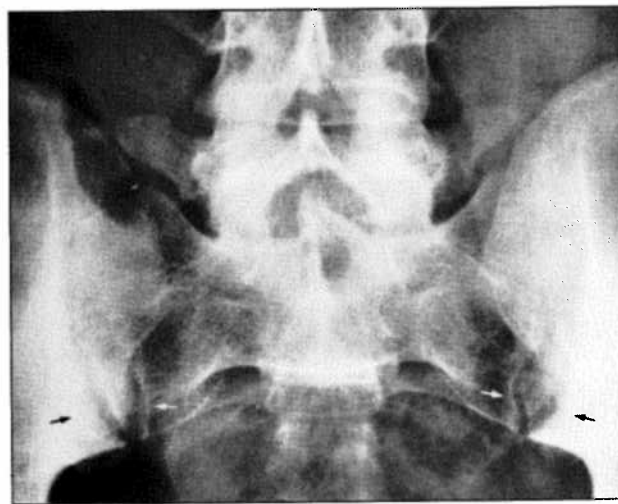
Radiograph of the sacroiliac joints demonstrating irregularity of the iliac side of the joint (black arrow) secondary to erosive changes in this patient with gout. This process is symmetrical. The cortical margin remains sharp without destruction on the sacral portion of the joint (white arrows).
